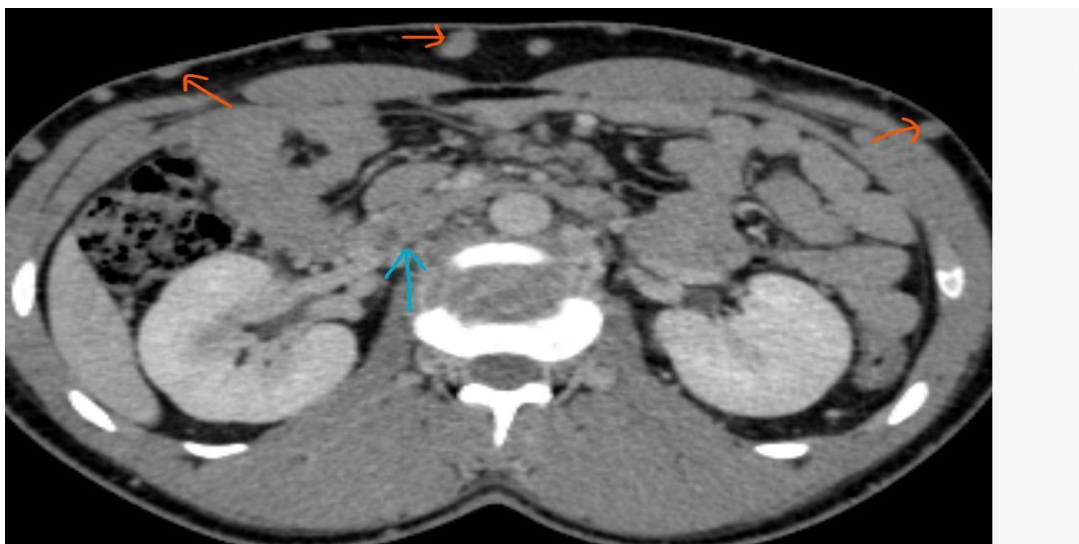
CT Scan abdomen showing non-visualization of infra-hepatic inferior vena cava (blue arrow) which is replaced by multiple collaterals in anterior abdominal wall (orange arrows)
